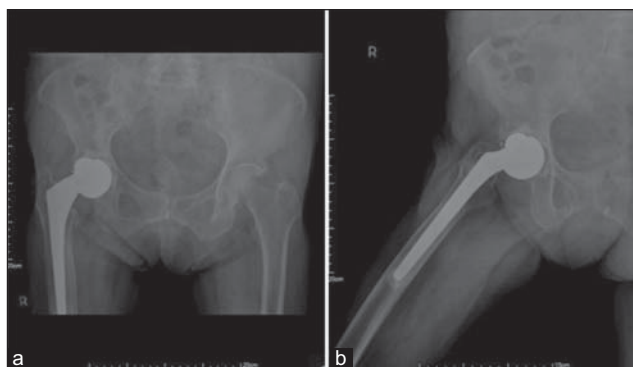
A 96-year-old female presented with bipolar prosthesis dissociation (disassembly of small head and polyethylene insert) with hip subluxation (a). The polyethylene cup was in extreme varus position. The retained locking ring could be found around the small head (b, the arrow). Arthritic change of acetabular surface could also be noted in preoperative plain film
